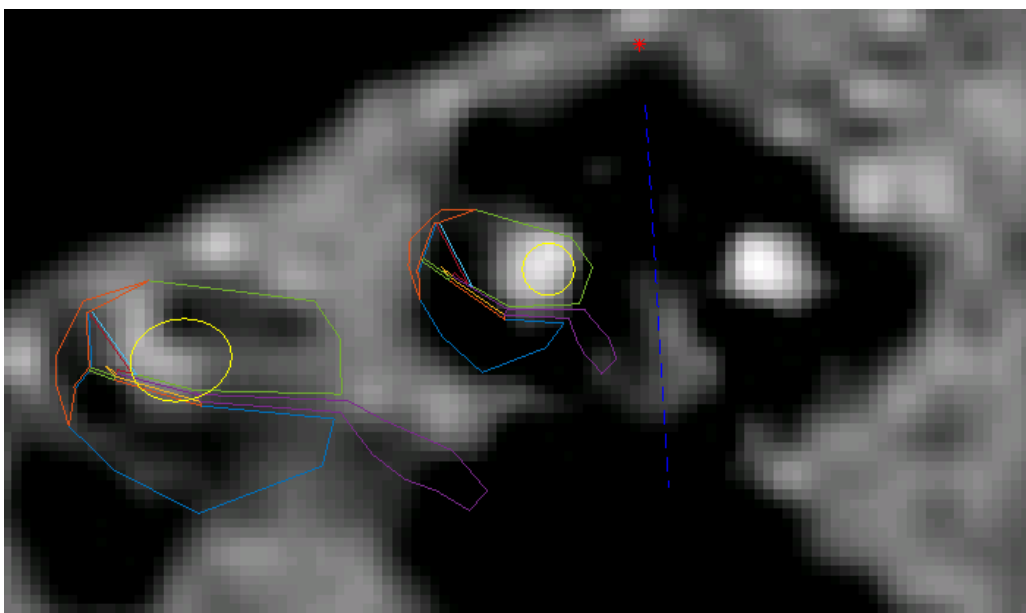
Cochlear structures and electrode array after the modification process. Multiple points were adapted to improve the correspondence between the cochlear structures and the cochlear duct visible on the CT image. Note the improvement in the accuracy of the electrode array and the cochlear duct, in comparison to Figure 3.1.
